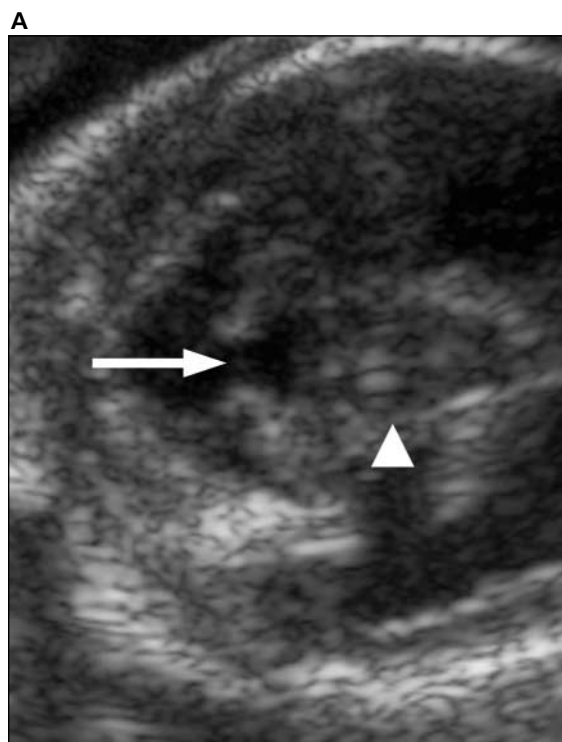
Images from a fetus of a twin pregnancy at 32 gestational weeks with callosal agenesis (case 7). A, Coronal sonogram showing ventriculomegaly with irregularity of ventricular margins, consistent with periventricular heterotopia or a destructive process. B, Coronal SSFSE T2-weighted image confirming periventricular nodular heterotopia. Bilateral closed lip schizencephaly (arrows), open lip schizencephaly (partially shown; arrowhead), and a diffusely abnormal gyral pattern are only apparent on fetal MRI.
